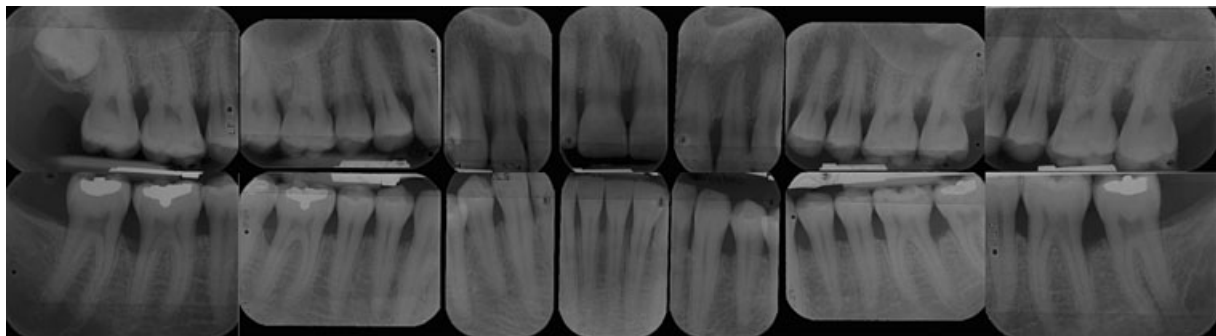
Radiographs of the patient presented in Fig. 31-17.
